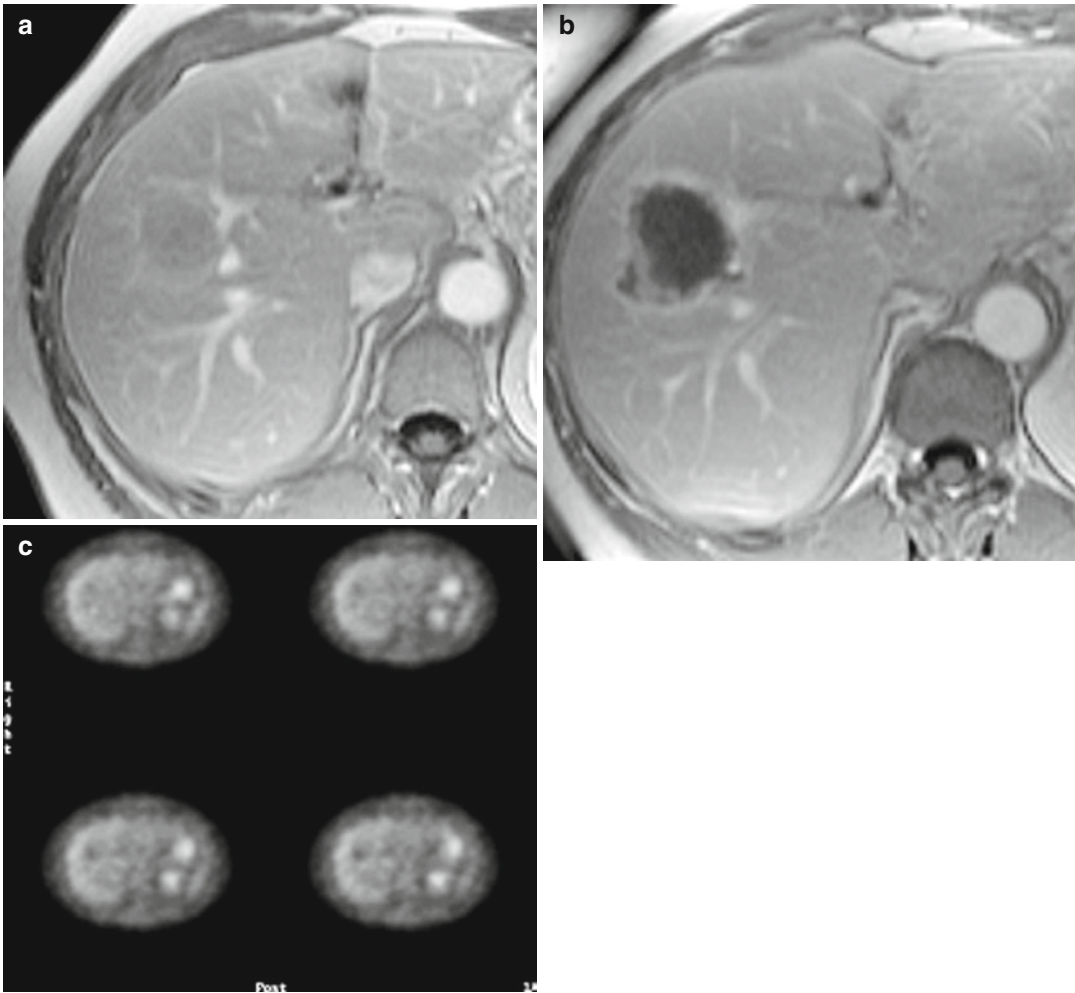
CT scan prior and 6 weeks post-RF ablation and additional PET scan of a recurrent unifocal liver metastasis of colorectal cancer: contrast-enhanced portovenous CT scan delineates unifocal recurrent liver metastasis in segment 8 of the liver (a; *arrow*). Contrast-enhanced portovenous CT scan 6 weeks post-RF ablation
